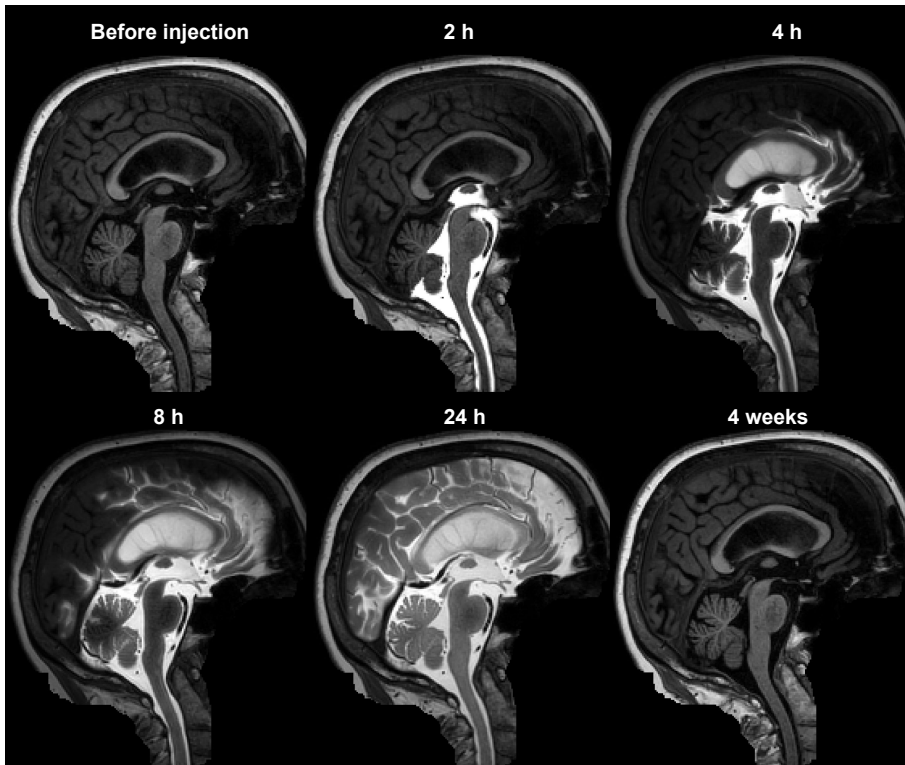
Sagittal slices (defaced) from CSF tracer-enhanced MRI of a patient from [159]. After 24 hours, the tracer has enriched the full brain and is cleared after four weeks.
